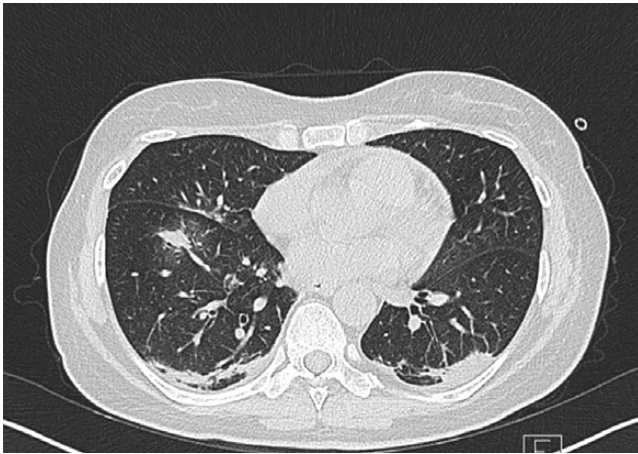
Chest computed tomography scan image showing lung opacities.
